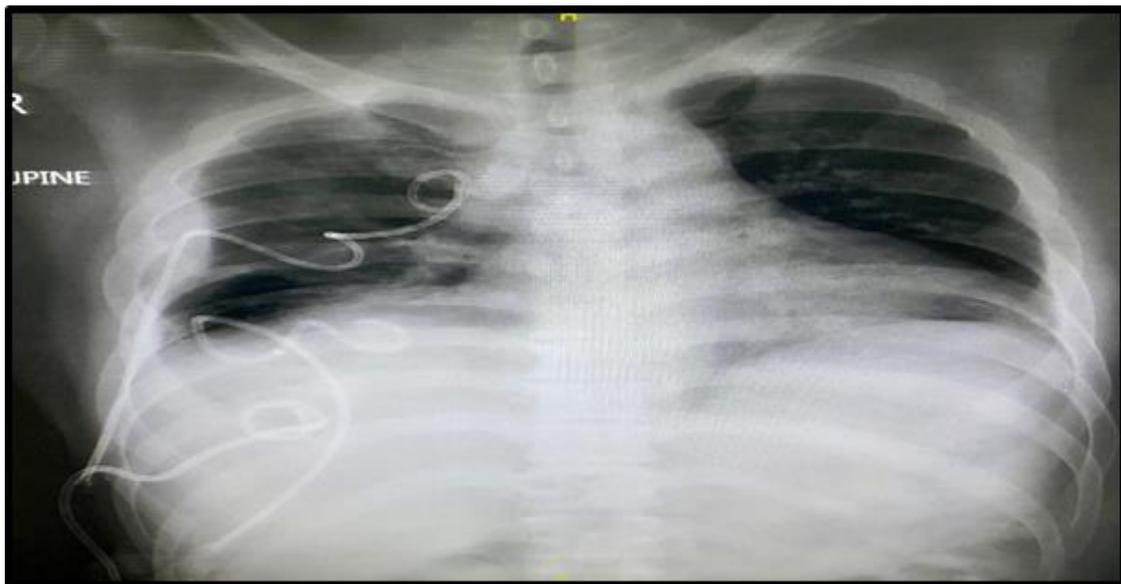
Chest X-ray improvement of the right lung effusion.
